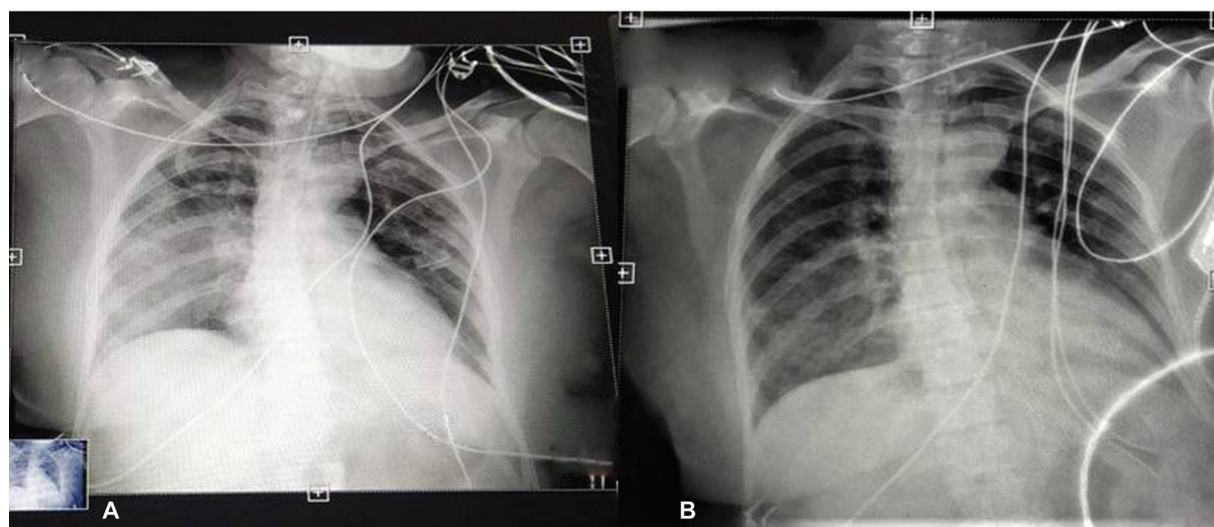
(A) Chest X-ray depicts features of pulmonary edema following intubation. (B) Chest X-ray depicts resolution of pulmonary edema.
